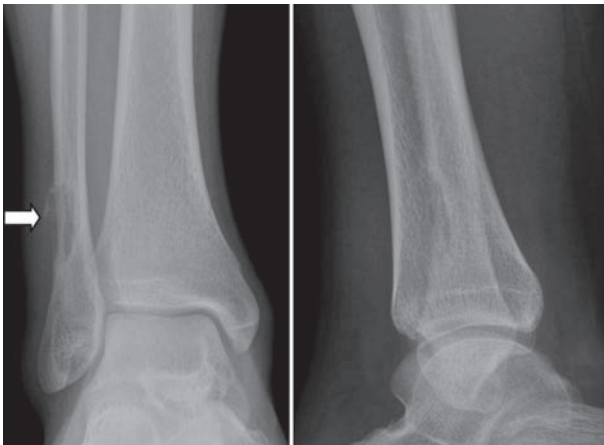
X-rays. On the left: antero-posterior view. Typical shell of cystic lesion (arrow). On the right: latero-lateral view showing an osteolysis of the anterior aspect of the fibula without bone sclerosis
